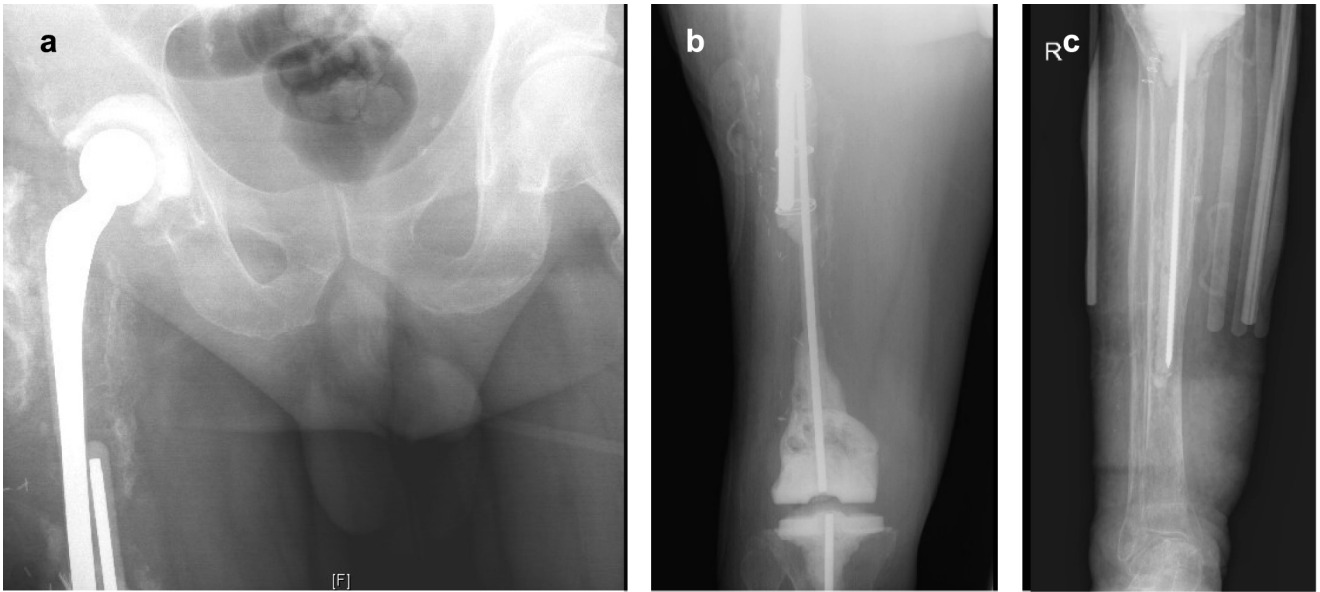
AP radiographs of the hip (a), femur (b), and tibia (c) demonstrating a dual-articulating total femoral spacer implanted in case/patient 2. AP, anteroposterior.
